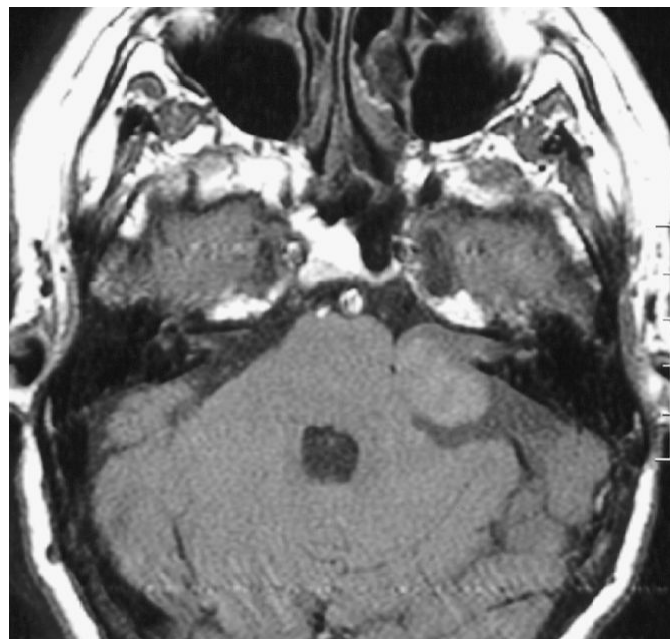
Acoustic Neuroma. Noncontrast T1-weighted axial image demonstrating round isointense mass at the left cerebellopontine (CP) angle.
